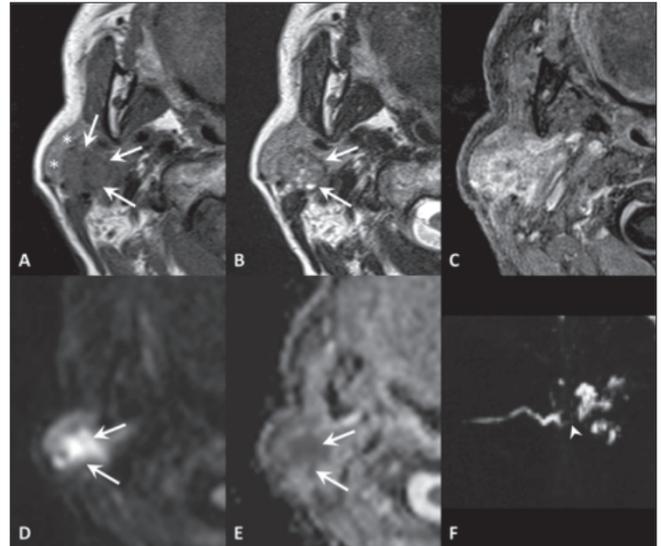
Focal obstructive sialadenitis. MR axial SE T1 (A), TSE T2 (B), VIBE after contrast administration (C), DWI b1000 (D) with ADC map (E); sialo-MR (maximum intensity projection in the sagittal plane) (F). Sudden onset of painful swelling of the right parotid gland. The focal inflamed area (arrows) can be detected because of its mass-effect on the adjacent gland tissue (asterisks), greater post-contrast enhancement and diffusion restriction. The MR sialography shows a filling defect (arrowhead) and intraglandular duct ectasia.
